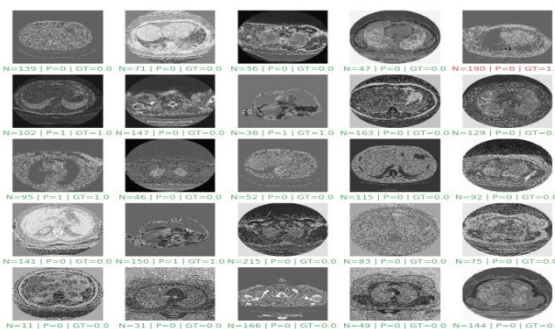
Randomly detecting COVID-19 on CT-scan images
